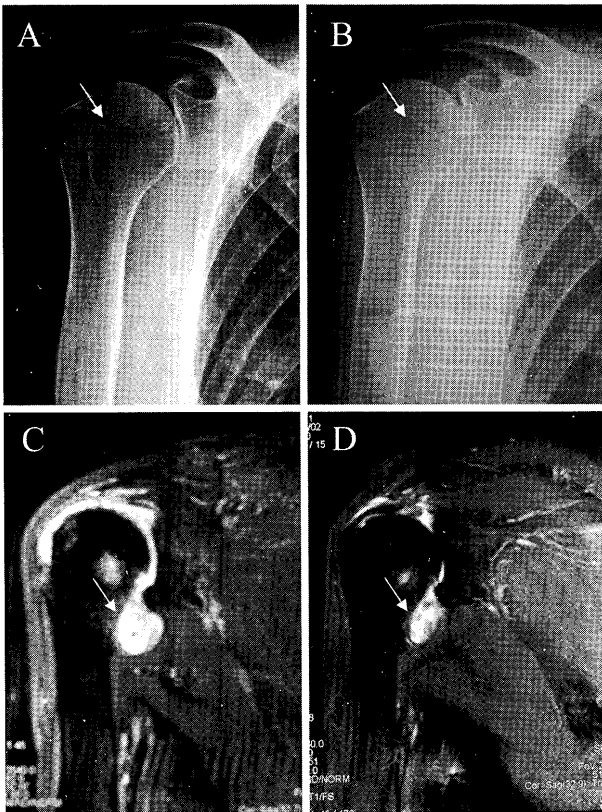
X-ray examination before (A) and after (B) the Ho: YAG laser treatment. MRI before (C) and after (D) the Ho: YAG laser treatment.
